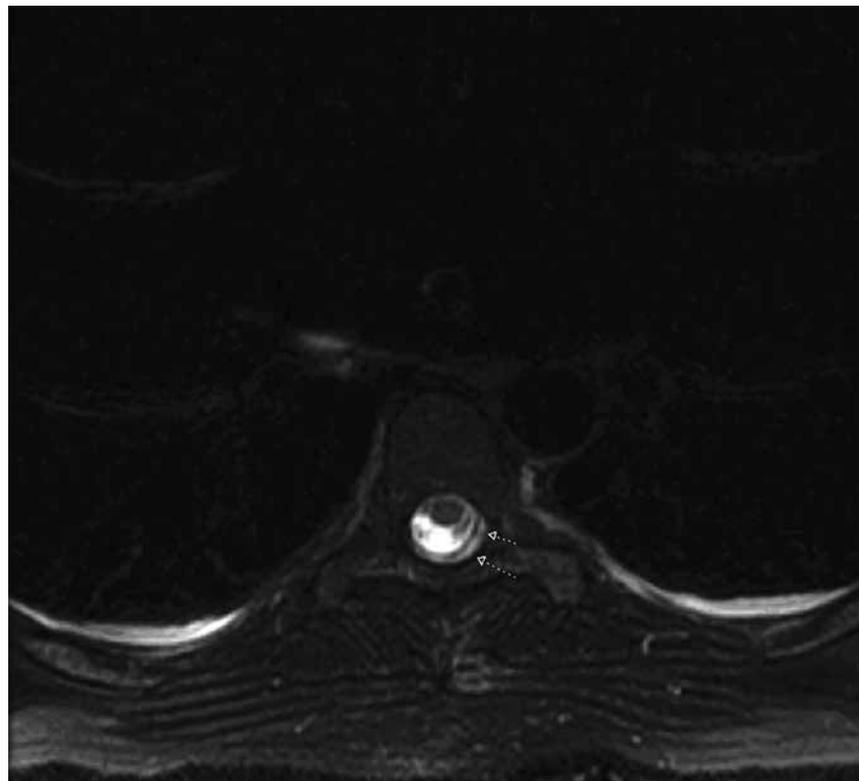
Transverse T2-weight magnetic resonance imaging of the thoracic spine showing a small amount of abnormal extradural fluid signal intensity along the dorsal epidural space at the level of T6 with no discrete dural defect identified.
